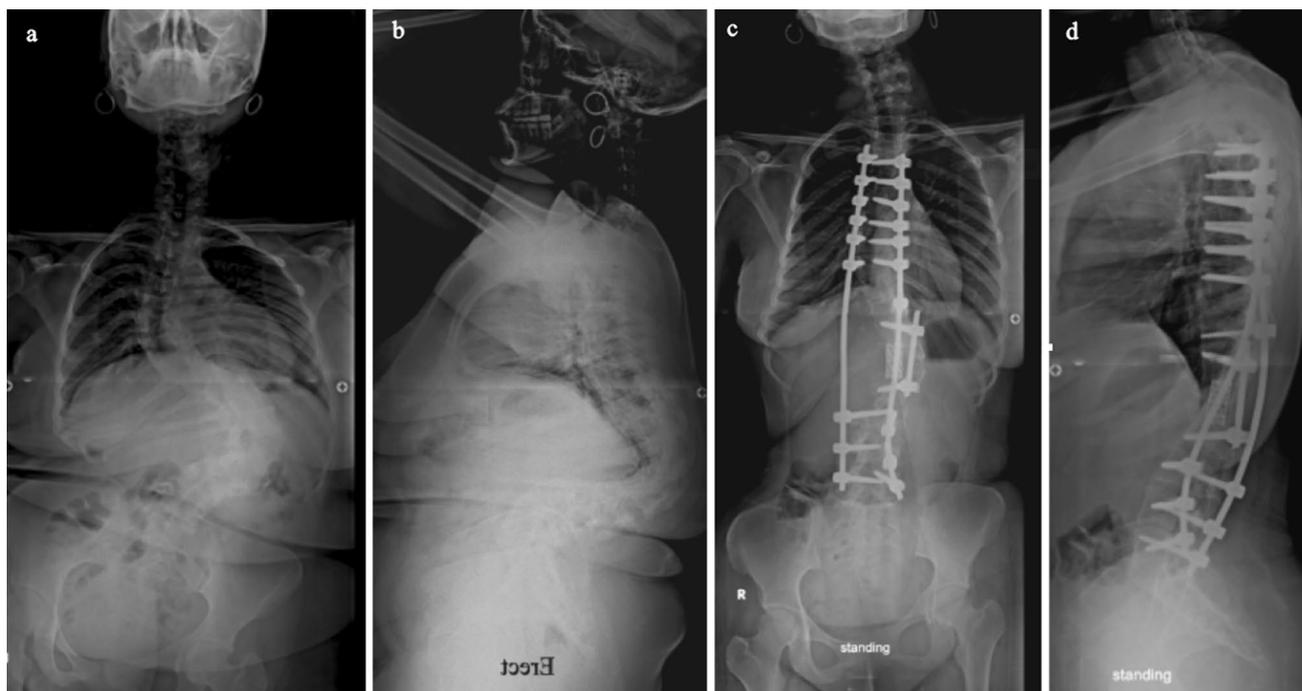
Female patient 21 years old with neglected congenital kyphoscoliosis: a, b preoperative AP and lateral whole spine radiograph showing severe scoliosis measuring 102° and thoracolumbar
